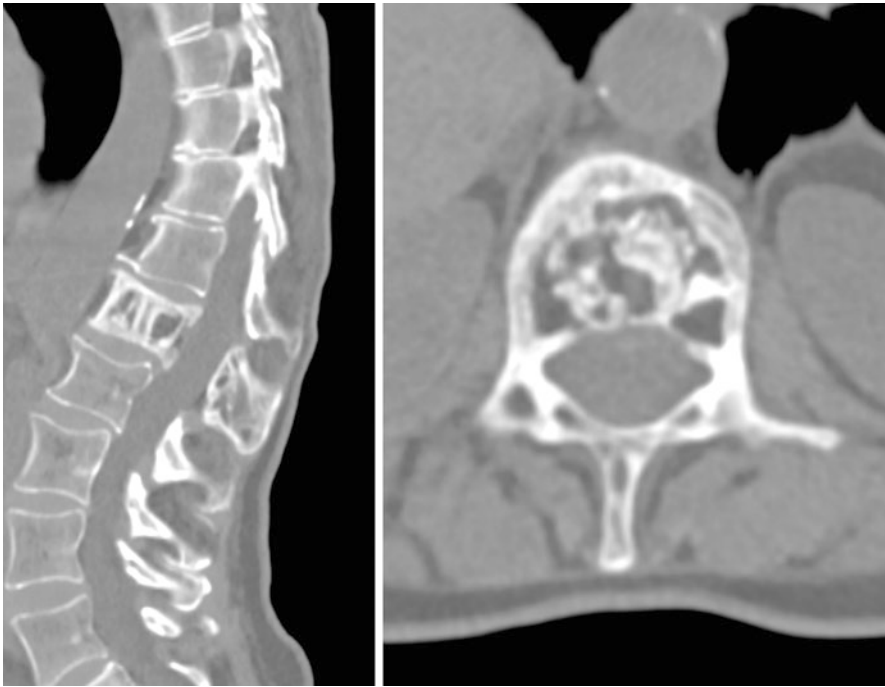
Sagittal and axial CT images showing periosteal apposition and endosteal resorption at L1 during the second phase of Paget's disease
